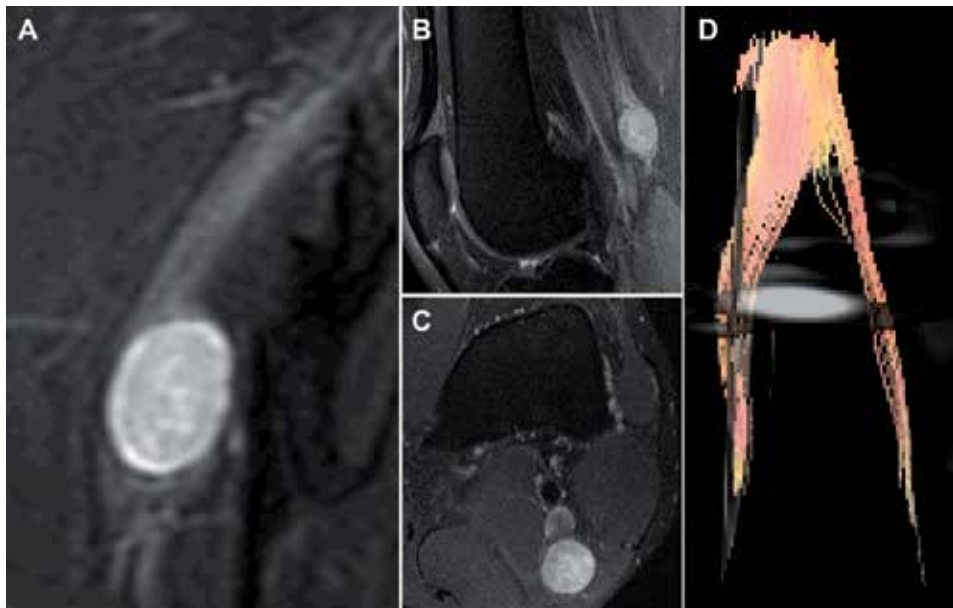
(A) and (B) T2 weighted MRI, sagittal view. (C) T2 weighted MRI, axial view. (D) Diffusion tensor imaging with tractography reconstruction. Large, round, and well-circumscribed peripheral nerve sheath tumor (schwannoma) arising from the left tibial nerve in the popliteal fossa. Tractography demonstrated intact nerve fascicles being splayed eccentrically posterior and medial to the tumor.
